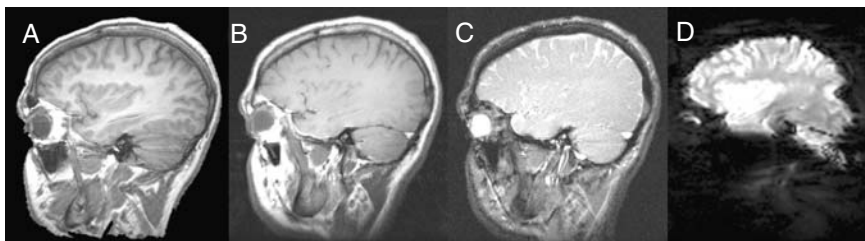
MRI scans (sagittal view) of the brain at around the level of the eye produced with different sequences to emphasize different tissue type and detail. A. High-resolution T1-weighted image shows excellent differentiation between grey and white matter. B. Low resolution T1-weighted image shows less of the detail. C. Magnetic Resonance Angiography (MRA) image shows major blood vessels and spaces with cerebrospinal fluid. D. Gradient echo echoplanar image acquired within a single shot and high speed in a functional MRI study. Note the difference in resolution between the structural MRI scans (A–C) and the functional MRI image (D).
